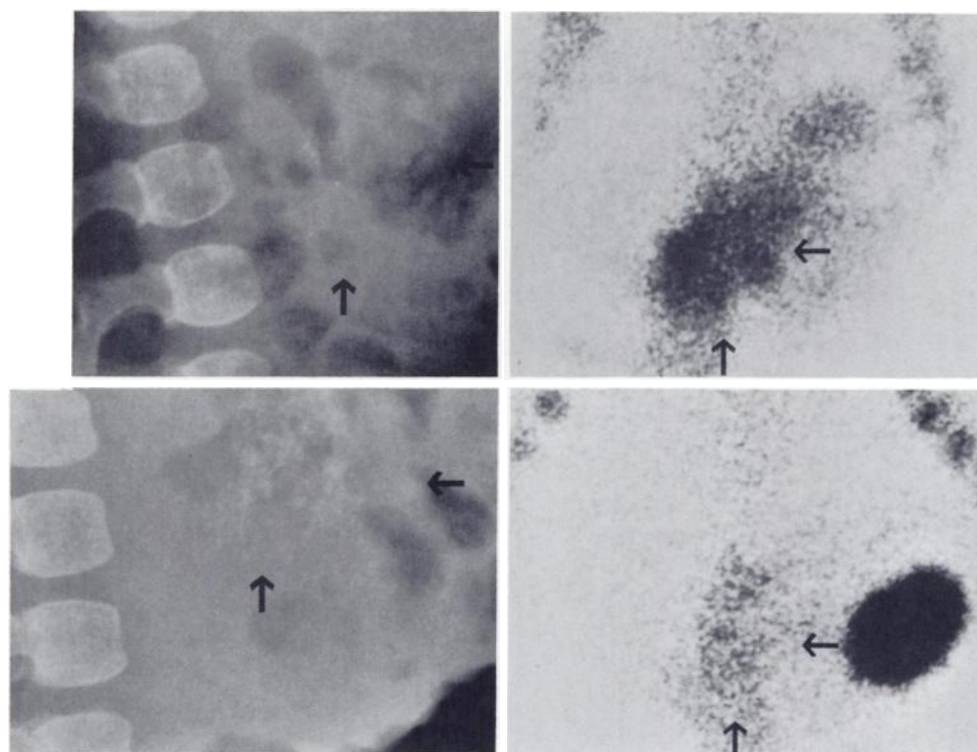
Stage 4 neuroblastoma shows increasing calcification by radiograph, but decreasing uptake of Tc-99m diphosphonate. Initial radiograph and bone image (upper); radiograph and bone image at 5 m of therapy. (Arrows indicate tumor area).
